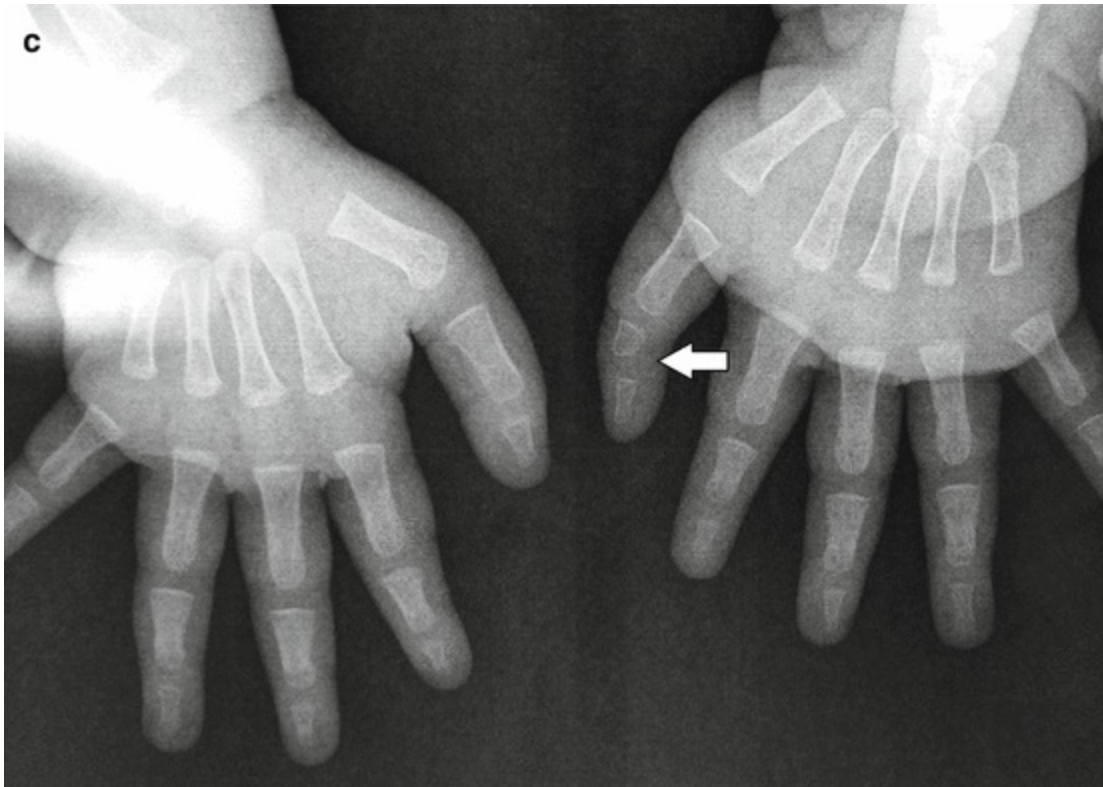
Triphalangeal thumb: (a) clinical dorsal view; (b) clinical palmar view; (c) radiography of both thumbs revealing anomaly of the left thumb
